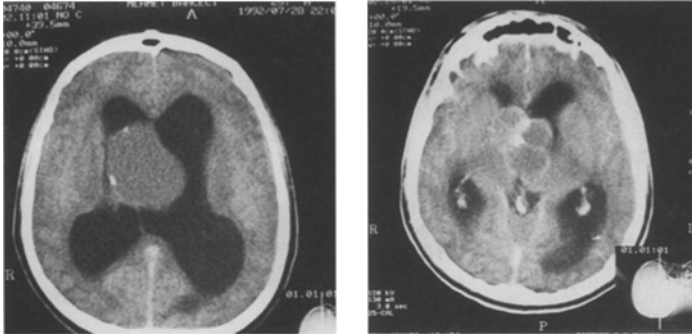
(a) Axial CT scan: A hypodense, homogeneous, smooth, 5 cm in diameter mass with calcification of the cyst wall is demonstrated at the anterosuperior region of the third ventricle in precontrast study (b) Axial CT scan: The mass shows slight enhancement following intravenous contrast injection.
